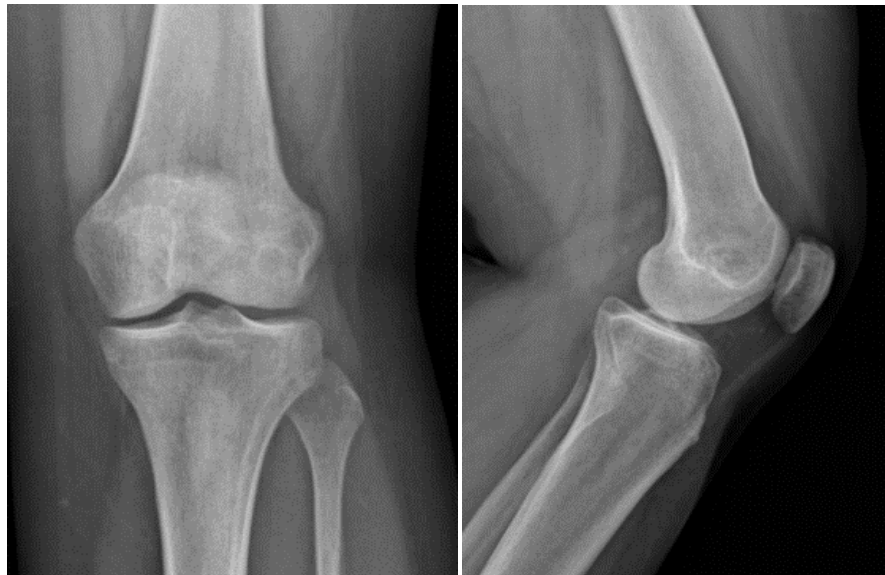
(a) AP and (b) lateral radiographs of the left knee with the presence of a radiolucent mass at the level of the lateral femoral condyle on the left side of approximately 5 mm diameter.
